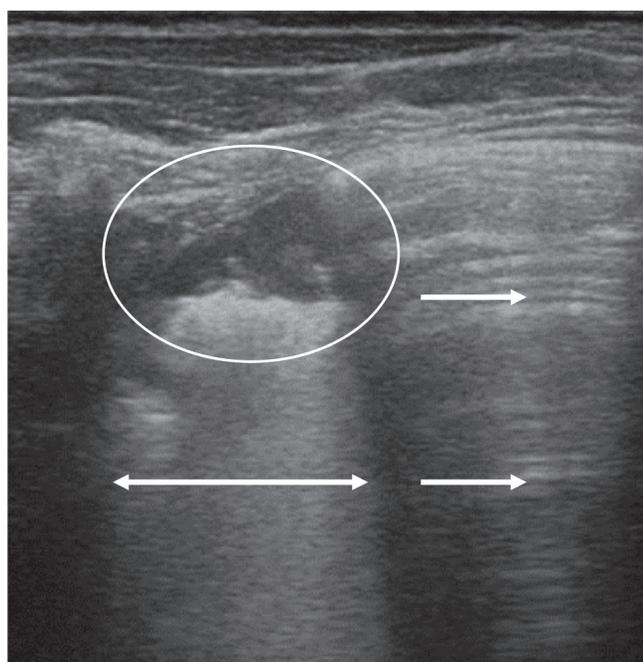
Lung ultrasound scan showing a subpleural consolidation (white circle), characterized by a hypoechoic area below the pleural line (white thin arrow). Below the point of discontinuity, large consolidated areas (white circle) appear with generalized white lung pattern (double head arrow). A-lines (white thick arrow) are visible in the close normal lung.
